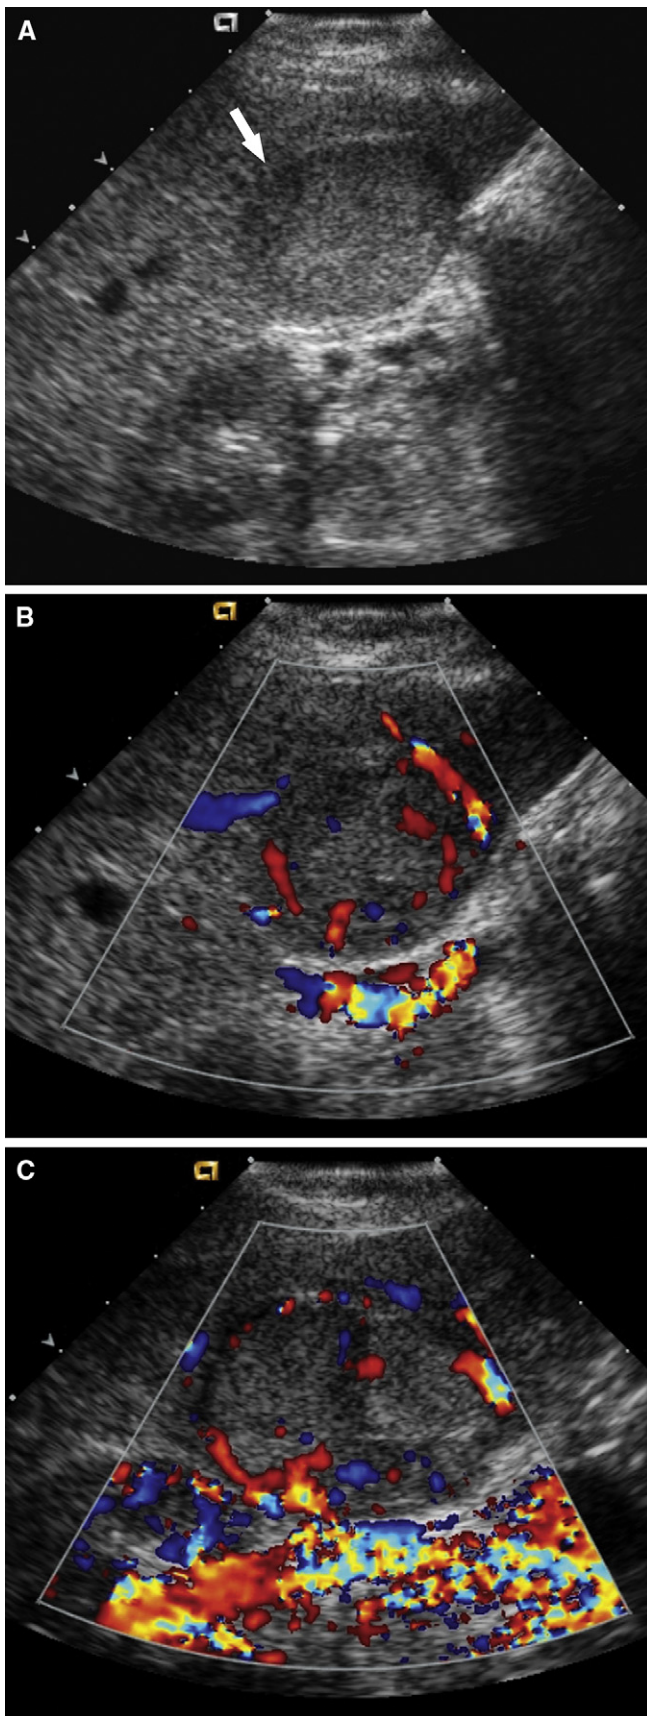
Hepatocellular carcinoma (HCC) on Doppler imaging in a 70-year-old woman with hepatitis C. (A) Transverse transabdominal
